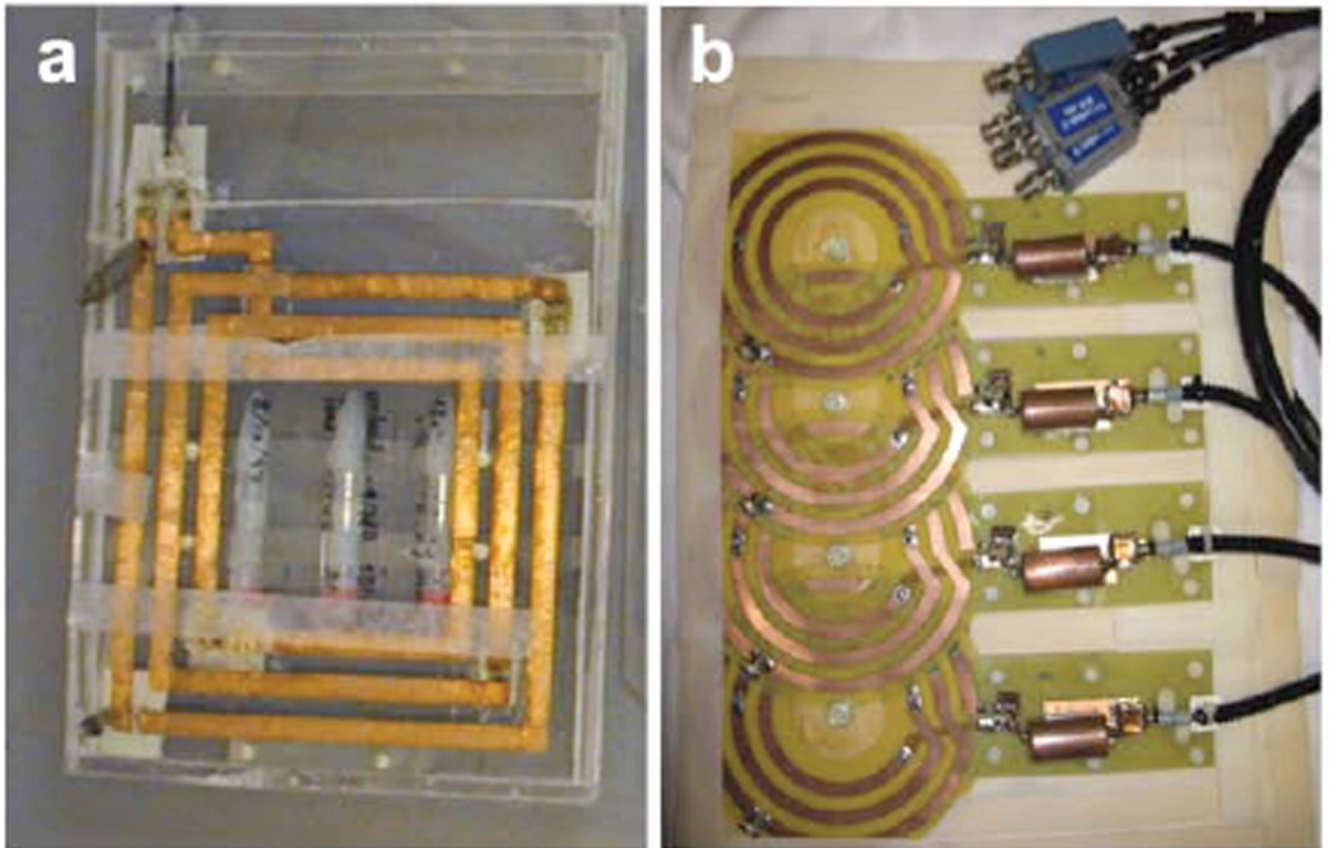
Custom-built coils for human cardiac ^{23}Na MRI at 1.5 Tesla (16.9 MHz). (a) Square 25×25 cm three-turn transmit/receive surface coil used for quantitative cardiac TSC studies employing adiabatic excitation (21). The coil has 3 embedded vials of saline gel to serve as sensitivity references, and a mount permitting exchange with a conventional cardiac ^1H coil for cardiac MRI (21,22). (b) A 4-channel ^{23}Na phased-array constructed from 15-cm, 3-turns coils for increased inductance at the lower ^{23}Na frequency (46). The detectors were fabricated on 0.25-mm thick flexible printed circuit board, with a separate 40-cm square single-turn transmit coil for excitation.
